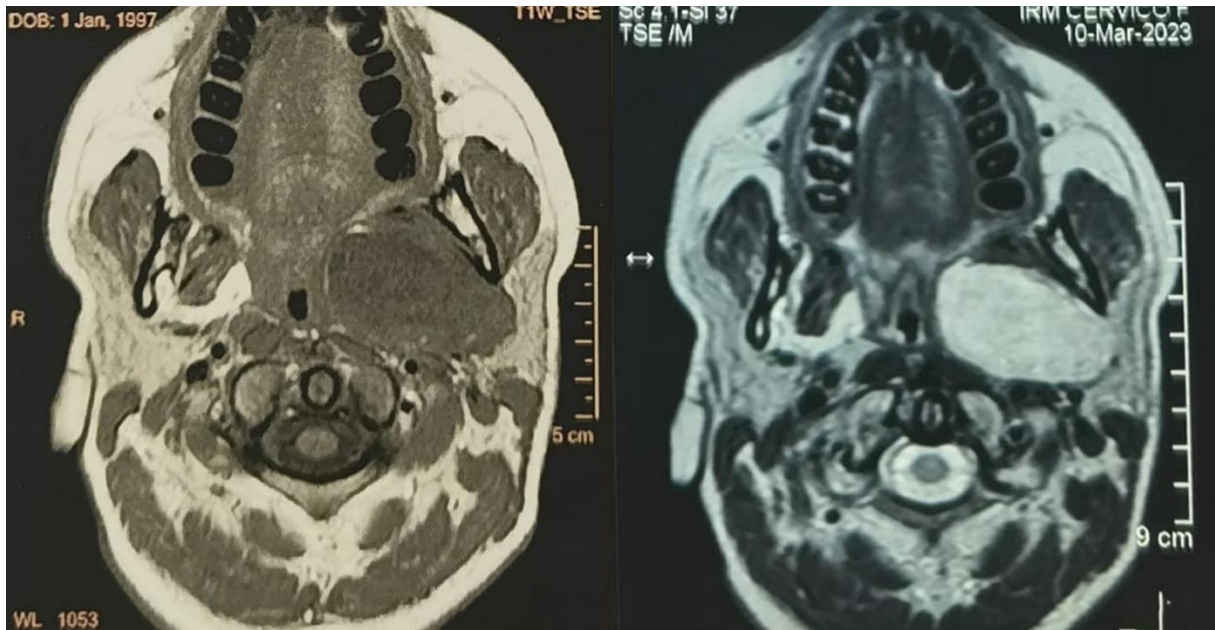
Axial MRI cuts showing a parapharyngeal mass, isointense T1 and hyper intense T2
